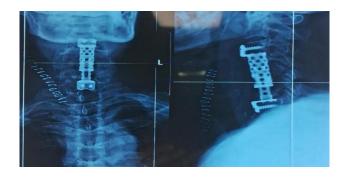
Post op X-ray-C4, C5, C6 corpectomy with cervical cage fusion.
